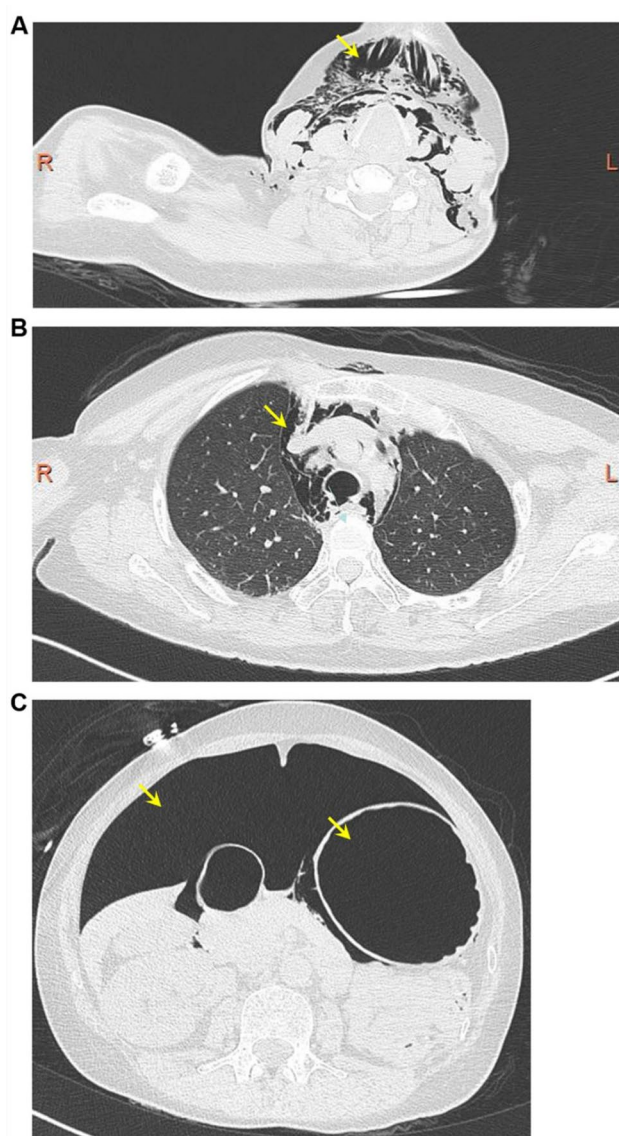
Head and chest CT showing subcutaneous emphysema, mediastinal emphysema, pneumothorax, tracheal rupture, pneumoperitoneum, and gastric distention. (A) Subcutaneous emphysema in the neck. (B) Mediastinal emphysema, right-sided pneumothorax, subcutaneous emphysema in the chest wall, and tracheal rupture. (C) Free gas shadows and gastric pneumoperitoneum are visible in the abdominal cavity (arrows). CT imaging revealed extensive and punctate collections of free gas in both the intraperitoneal and retroperitoneal spaces
